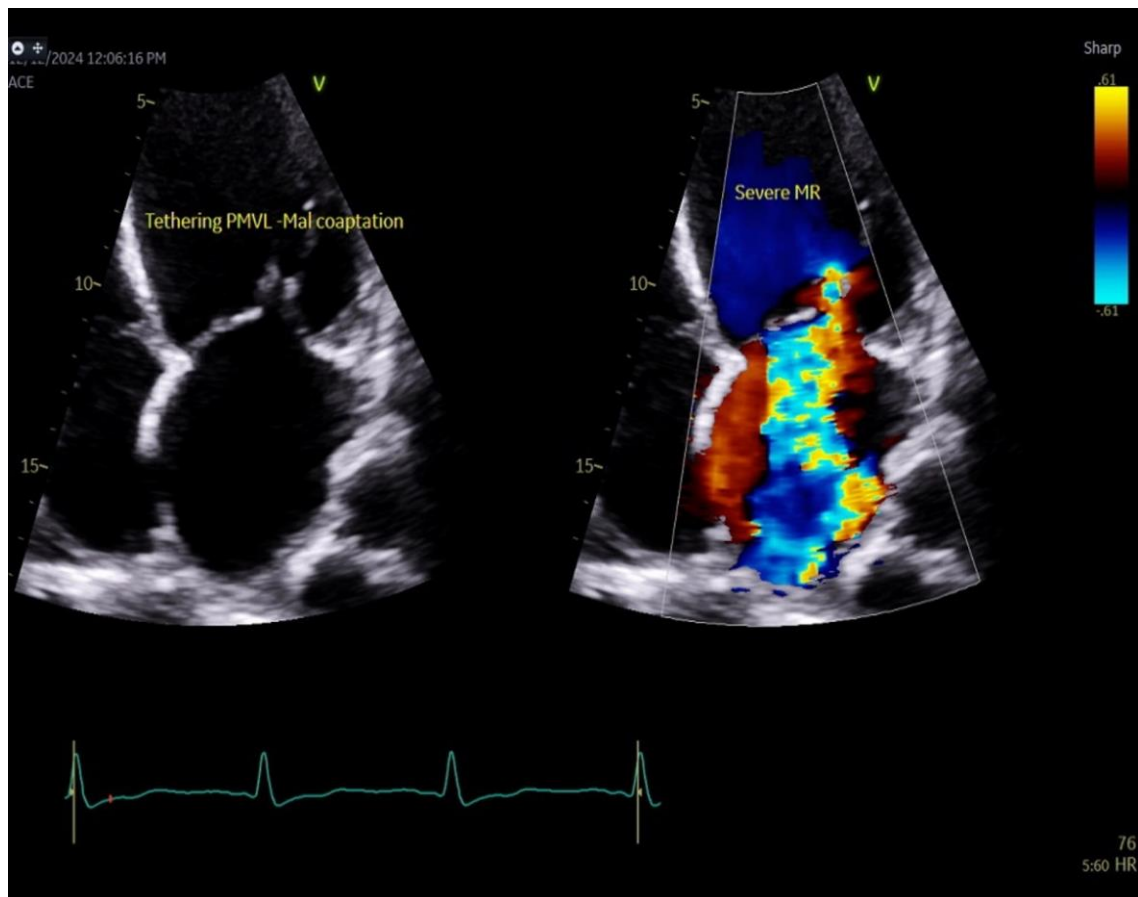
Transthoracic echocardiography focused 4 chamber view with color Doppler showing severe ischemic mitral regurgitation.
